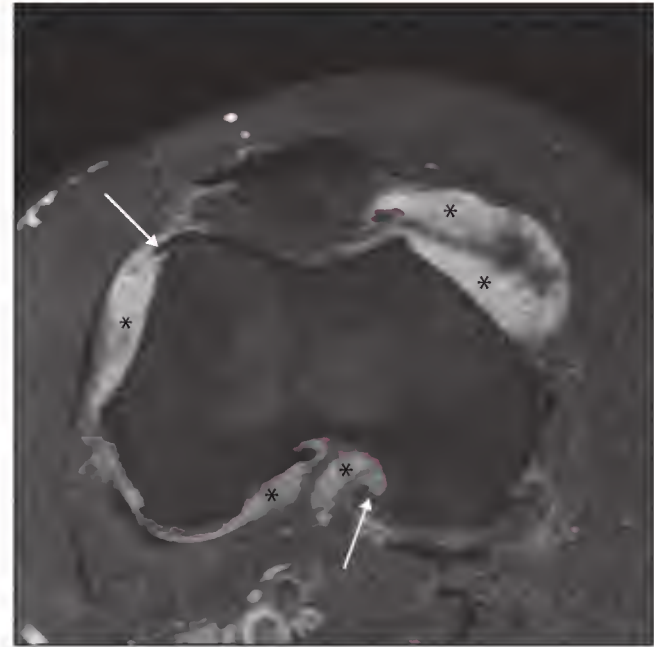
Axial T1-weighted fat-suppressed magnetic resonance image of the knee with gadolinium contrast. The high-signal synovitis is well demonstrated in the suprapatellar pouch and intercondylar notch (asterisks). Osteophytes are also seen (arrows).
